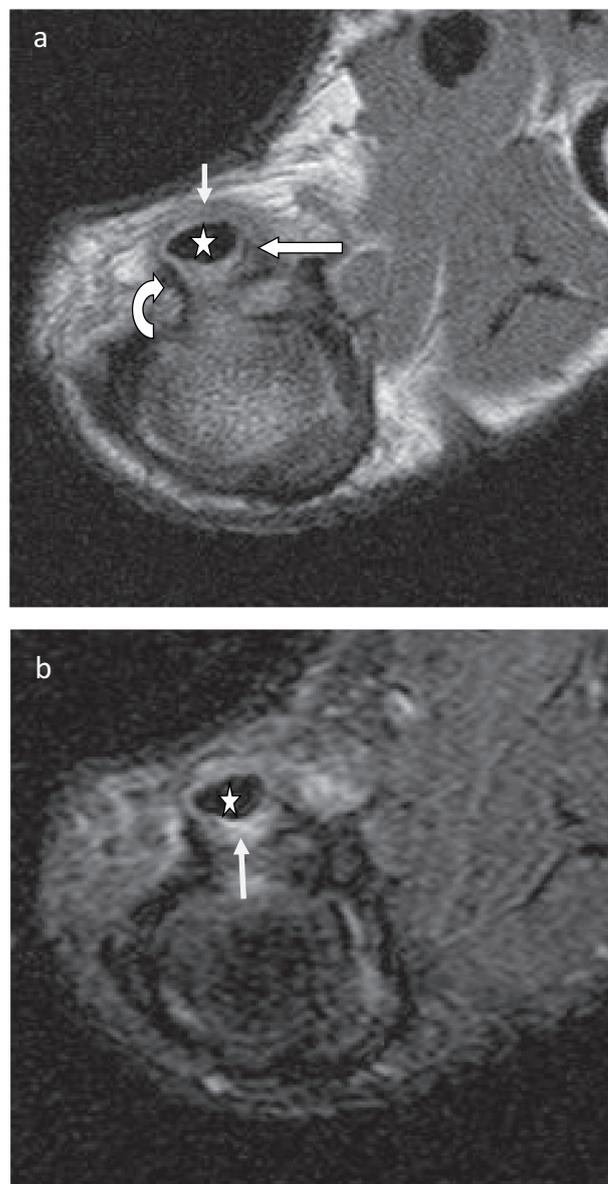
A 31 year old female nurse with thumb pain. (a) Axial proton density MR image demonstrates a tear of the first annular pulley (A1) (short arrow) at the level of the metacarpophalangeal joint with retracted radial (curved arrow) and ulnar (long arrow) limbs of the pulley. The flexor pollicis longus (FPL) tendon (star) is intact, but volarly displaced from its expected location. (b) Axial fat-saturated proton density sequence at the same level demonstrates fluid (arrow) in the FPL tendon sheath (star), consistent with tenosynovitis.
